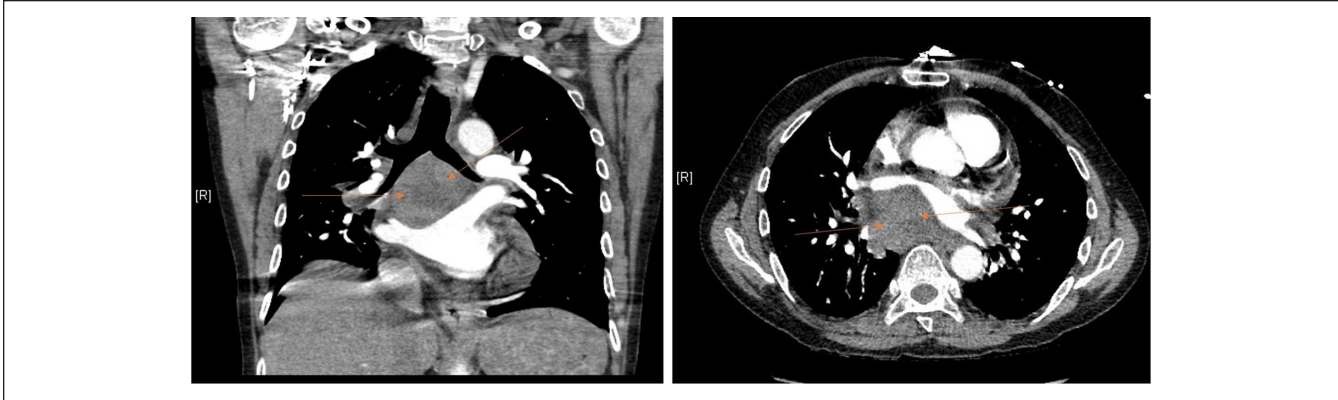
(A) Computed tomography (CT) chest without contrast coronal view demonstrating large mediastinal lymphadenopathy (orange arrows). (B) CT chest without contrast axial view also demonstrating large mediastinal lymphadenopathy (orange arrows).
